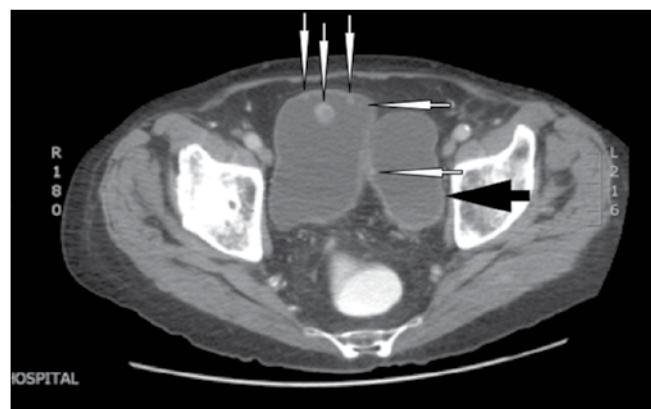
Computed Tomography scan showing multiple lesions (white arrows) within urinary bladder and a large bladder diverticulum (black arrow).
